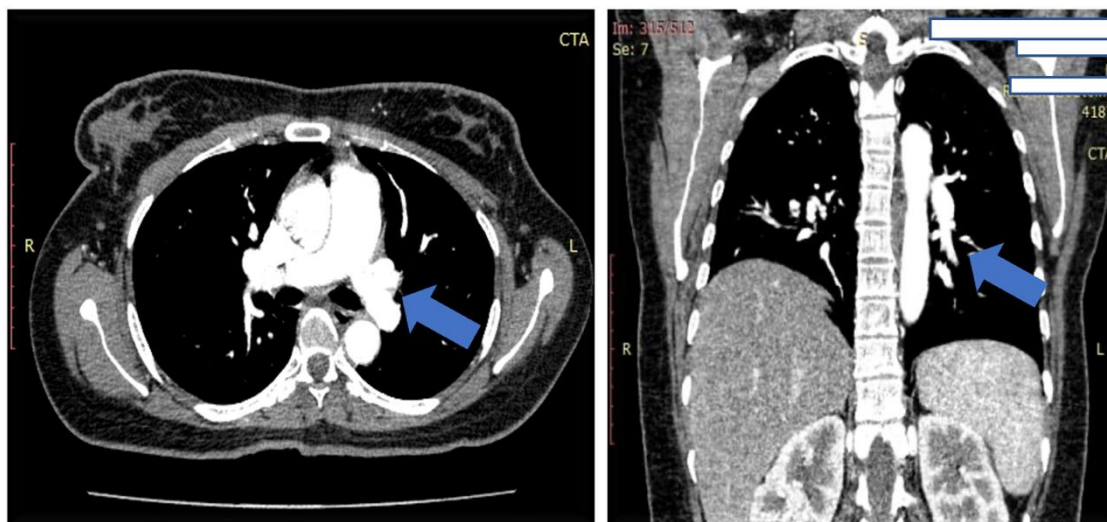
CT Pulmonary Angiography (CTPA) 3 months after initial anticoagulant therapy. Left: Axial view, the right and left pulmonary arteries were completely filled with contrast, no filling defects were seen. (blue arrow); Right: Coronal view, the left pulmonary artery can be seen completely filled with contrast, no filling defect is seen.
